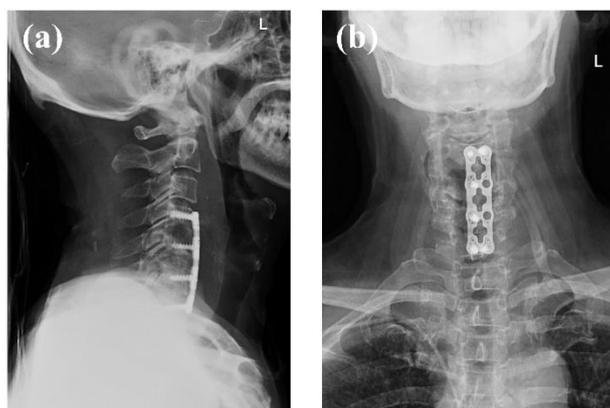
Postoperative X-ray shows that the curvature of cervical spine becomes straight; The bone density of some vertebrae in C4 and C5 decreased; Metal internal fixation shadow can be seen in C4-7 vertebral body, internal fixation is not loose or broken, and vertebral space is normal.
